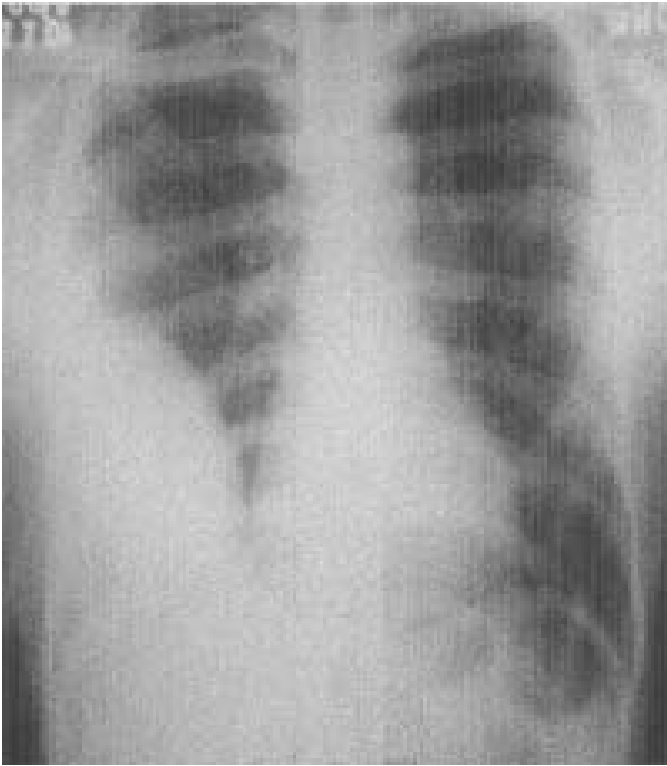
Chest radiograph PA view showing D-shaped opacity suggestive of loculated effusion.
